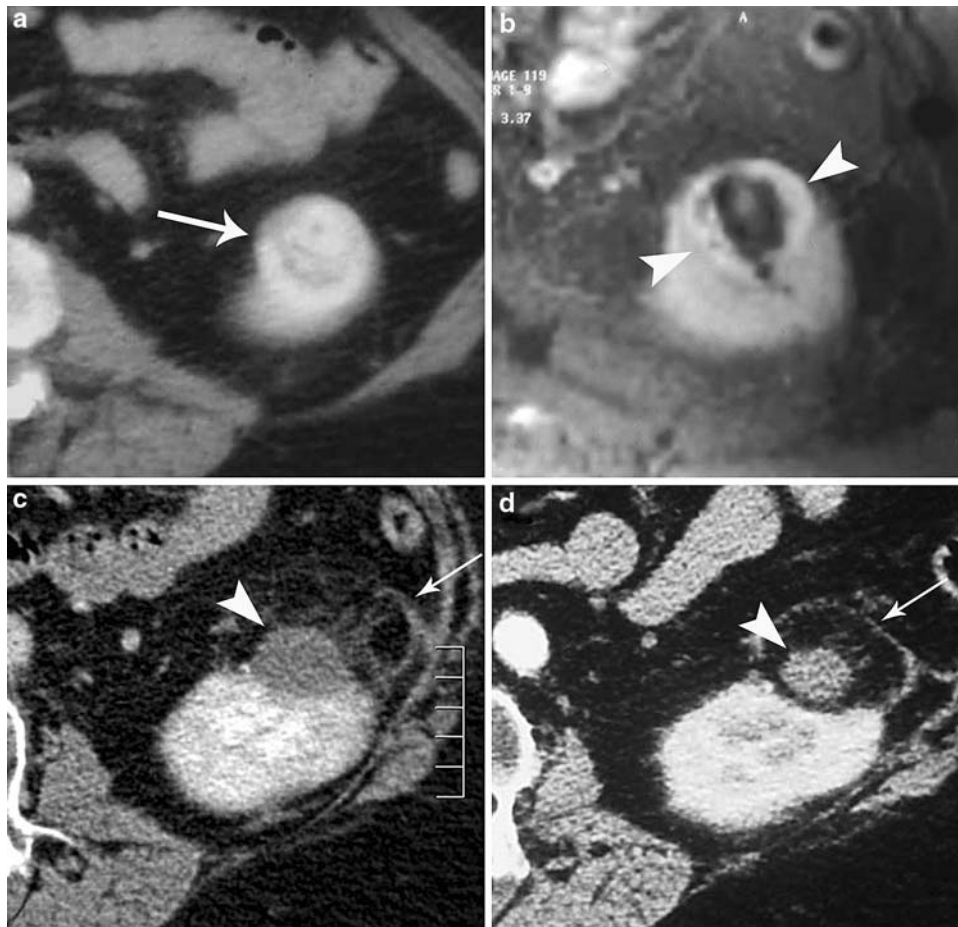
Images obtained in a 65-year-old patient with a history of right radical nephrectomy for renal cell carcinoma and surgery for subsequent metastases (liver, right renal fossa, left adrenal). (a) Contrast-enhanced CT image showing a new 35-mm tumor of the lower pole of the left kidney (arrow). This tumor was treated by US-guided percutaneous RFA. (b) Fat-saturated gadolinium-enhanced MR image obtained 2 days after the ablation procedure showing residual enhancing tumor tissue on the periphery of the treated area (arrowheads). A second US-guided percutaneous RFA was performed
